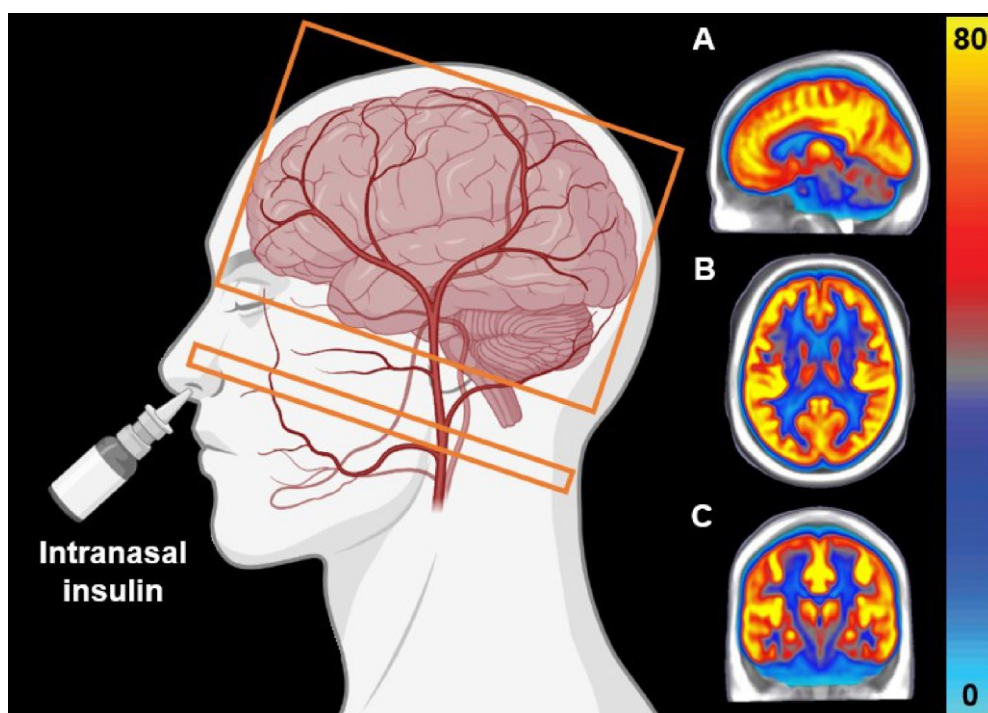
Example of a perfusion-weighted image using pseudo-continuous arterial spin labeling magnetic resonance imaging (pCASL-MRI). The orange rectangular boxes represent the imaging box and labeling plane perpendicular to the vertebral and carotid artery. Three-dimensional cerebral blood flow maps (CBF in ml/100 g brain tissue/min, scale shown by color bar) were obtained: (A) sagittal view, (B) axial view and (C) coronal view. These CBF maps were obtained in the fasted state to assess brain vascular function. Moreover, brain insulin responsiveness was quantified by the change in CBF before and 30 minutes after intranasal insulin application.
